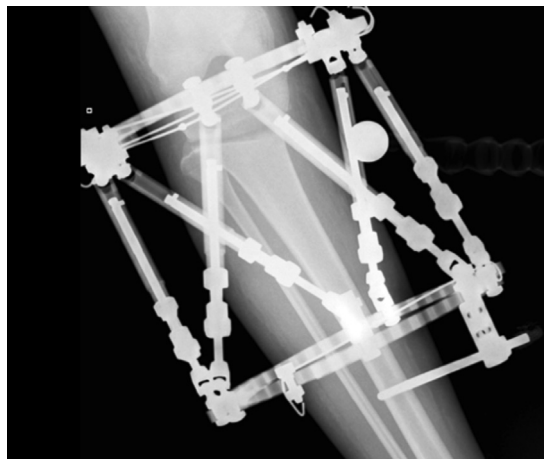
Immediate post-operative radiograph showing TSF placement on the affected limb.
